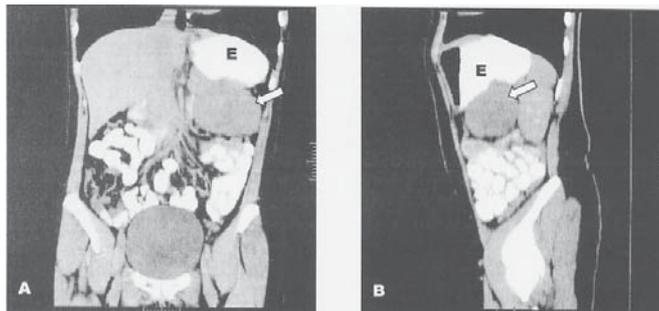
Multislice computed tomography with coronal (A) and sagittal (B) reconstructions shows a large heterogeneous low-attenuation solid lesion (arrows) in contact with the gastric body posterior wall. E= stomach
